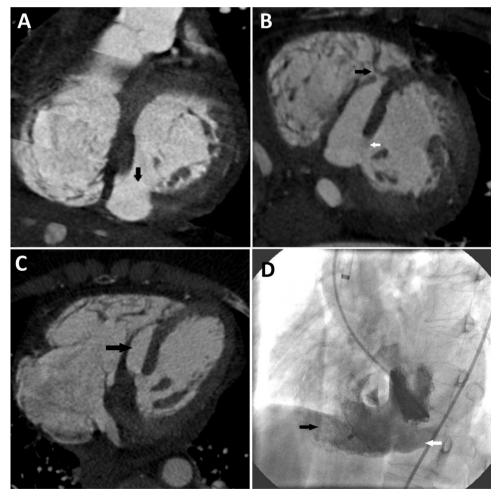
(Panel A) Cardiac CT short axis view demonstrating a rupture in the basal inferior segment of the interventricular septum communicating to a contrast-filled sac (arrow). (Panel B) Cardiac CTA in the short axis plane demonstrates the post-infarct myocardial rupture in the basal infero-septal segment of the interventricular septum (white arrow). The rupture dissects through the interventricular septum creating a VSD into the right ventricle (black arrow). (Panel C) Cardiac CTA in the axial plane demonstrates the large post-infarct VSD (black arrow). (Panel D) Fluoroscopic image after contrast administration into the left ventricle (ventriculogram) demonstrating the Amplatzer Septal Occluder within the VSD and persistent filling of a portion of the pseudoaneurysm (white arrow) with mild residual shunting into the right ventricle (black arrow).
